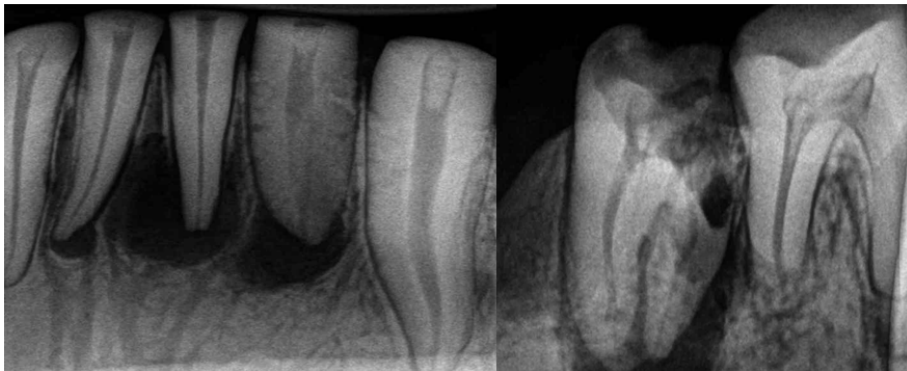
Radiovisiography shows reduced enamel, coronal intrapulpal calcifications, pulpal exposed, multiple periapical abscess
